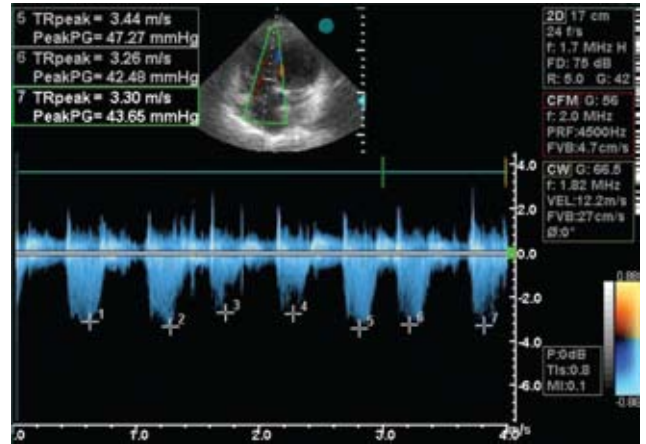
Predischarge Doppler echocardiography (May 30, 2010).
